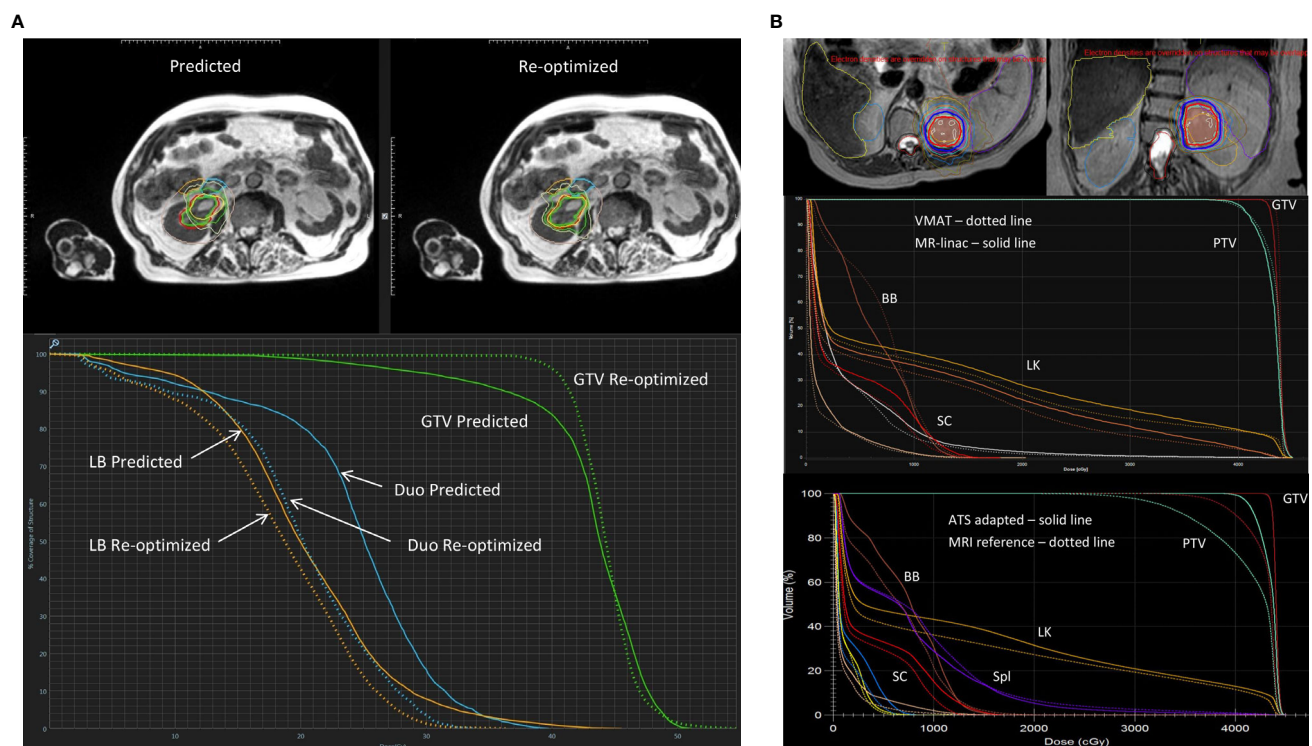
Representative MRgRT treatment plans for RCC patients with (A) 40 Gy in 5 fractions on a 0.35T MR-linac (MRIdian, ViewRay, Oakwood Village, OH) and (B) 42 Gy in 3 fractions on a 1.5T MR-linac (Unity, Elekta, Stockholm, Sweden). (A) Top panel showing axial MRIs of a predicted and re-optimized plan of a right-sided RCC: GTV (green contour), duodenum (blue contour) and large bowel (orange contour); Bottom panel showing the corresponding DVH of the predicted (solid line) and re-optimized (dotted line) plans with improved GTV (green) coverage, and sparing of the duodenum (Duo - blue) and large bowel (LB - orange). Reproduced with permission from AME Bruynzeel (Amsterdam UMC). (B) Axial (left) and coronal (right) MRI treatment plan of a left-sided RCC showing ITV (brown color wash) and PTV (light green color wash) with isodose lines: 42Gy (red) and 36Gy (blue); Middle panel showing a DVH of VMAT (dotted line) and 1.5T MR-linac treatment plans (solid line); Bottom panel showing a DVH of an ATS adaptive (solid line) and reference plan (dotted line) with improved ITV (dark red) and PTV (light green) coverage, and equivalent sparing of the left kidney (LK - orange), spleen (Spl - purple), bowel bag (BB - brown) and spinal cord (SC - bright red). Reproduced with permission from C Tang (MD Anderson Cancer Center) (31).
